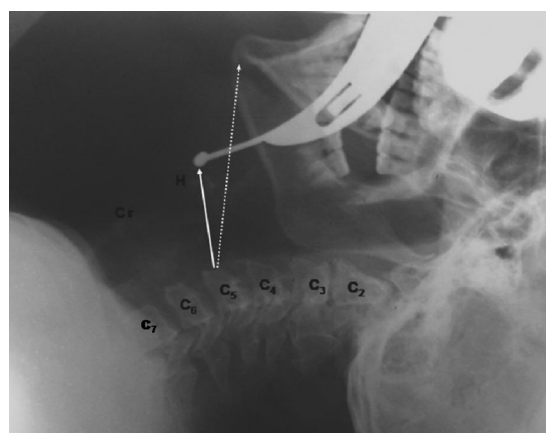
Lateral radiograph of the head and neck taken at the best laryngoscopic view with the No. 2 Macintosh curved blade (MCB) (solid arrow). Larynx visualization space from C5 to MCB tip marked. Mentovertebral distance (dotted arrow) from C5 to mentum to measure anterior displacement of the jaw during laryngoscopy. C = cervical vertebrae; Cr = cricoid cartilage; H = hyoid body.
